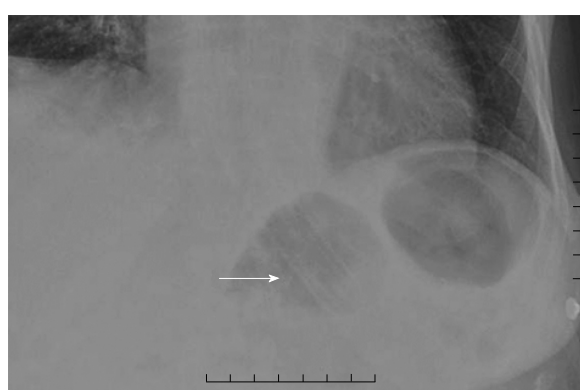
Chest X-ray demonstrating migration of the esophageal stent to the level of the gastroesophageal junction (arrow).
